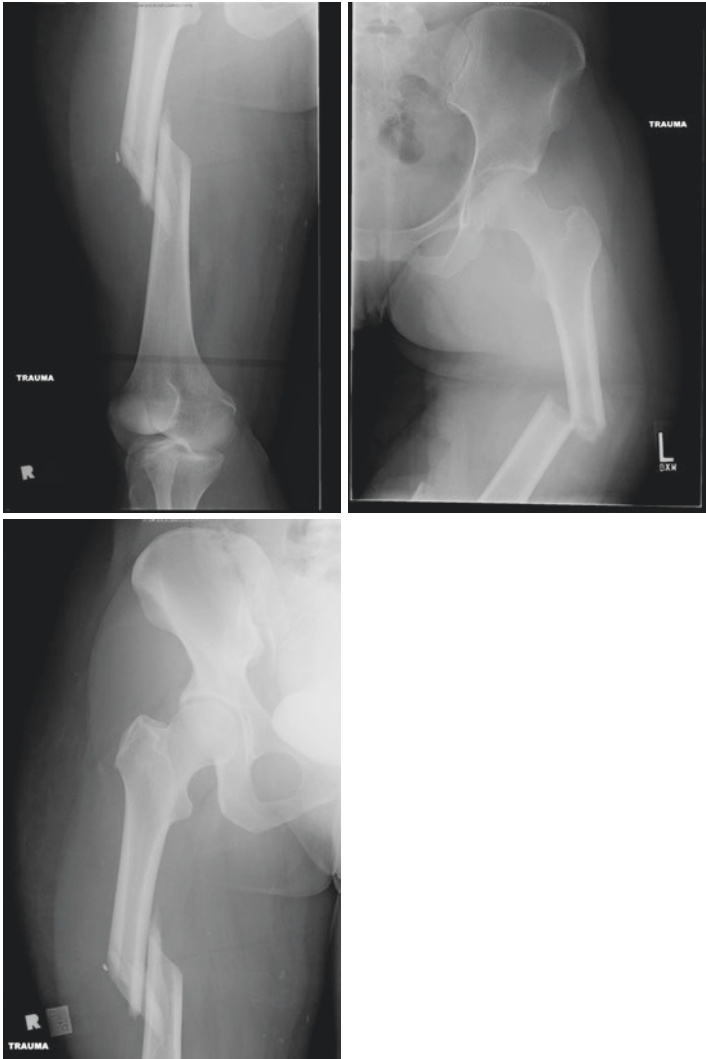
Representative radiographic images of femoral shaft fractures in skeletally mature patients
